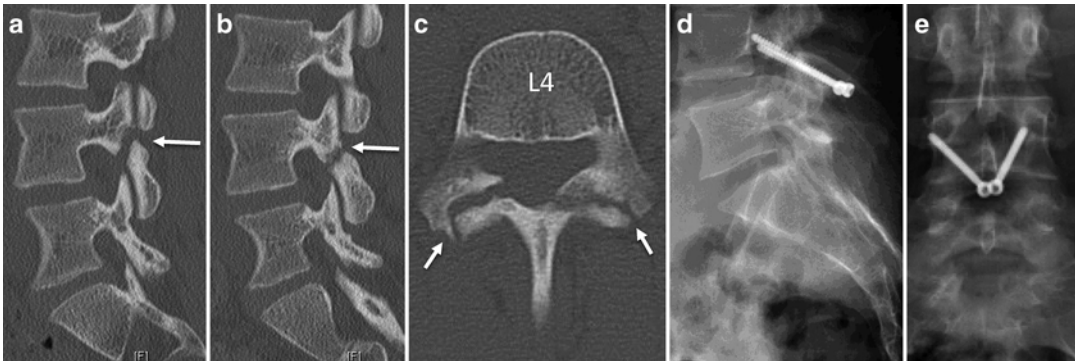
Radiographs of a 16-year-old female with a 2-year history of chronic low back pain worse in extension. Right (a) and left (b) CT sagittal reconstruction and axial (c) of L4 demonstrate bilateral L4 pars defects (arrows). Postoperative lateral (e) and AP (f) following
